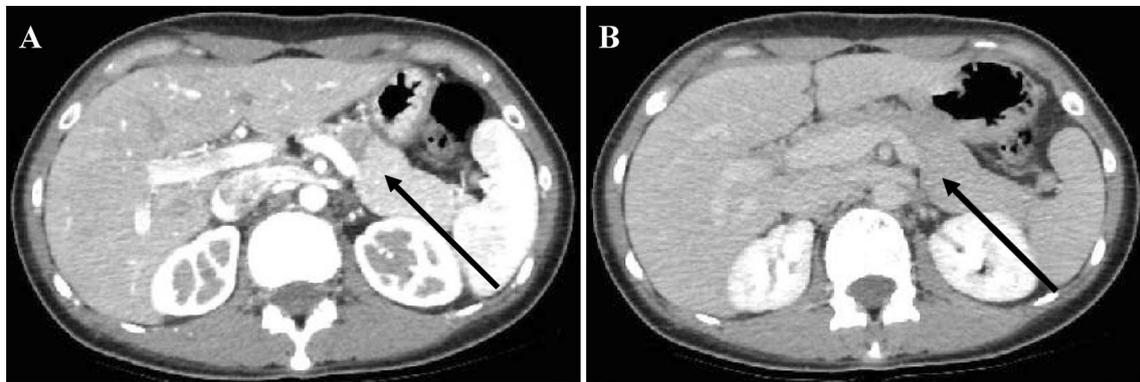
Contrast-enhanced computed tomography. a Homogenous hypovascular tumor in the arterial phase in the pancreatic body (arrow). b Iso-vascular tumor in the delayed phase (arrow)
